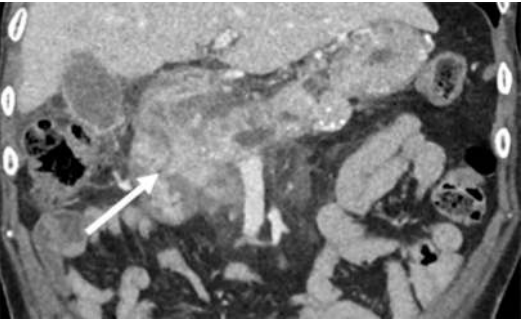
Coronal multiplanar reconstruction contrast-enhanced CT showing inflammatory wall thickening (arrow) centered on the pancreaticoduodenal groove region with changes of peripancreatic inflammation in a case of groove pancreatitis
